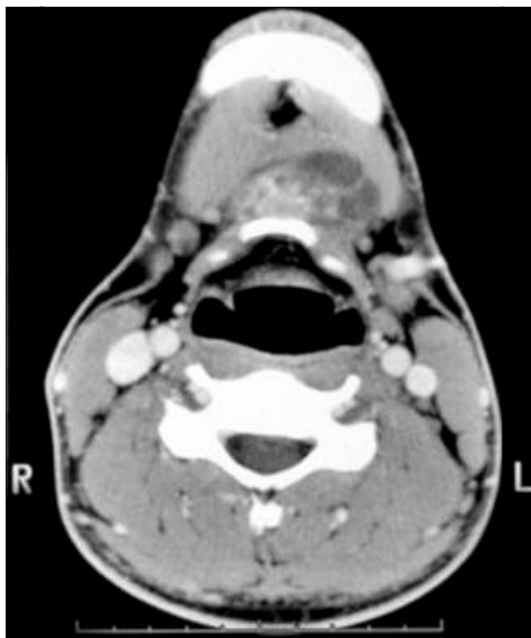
Neck CT shows about 3.5 × 1.5 cm sized well-defined cystic lesion with internal septation, solid portion, and calcification at hyoid bone level.
